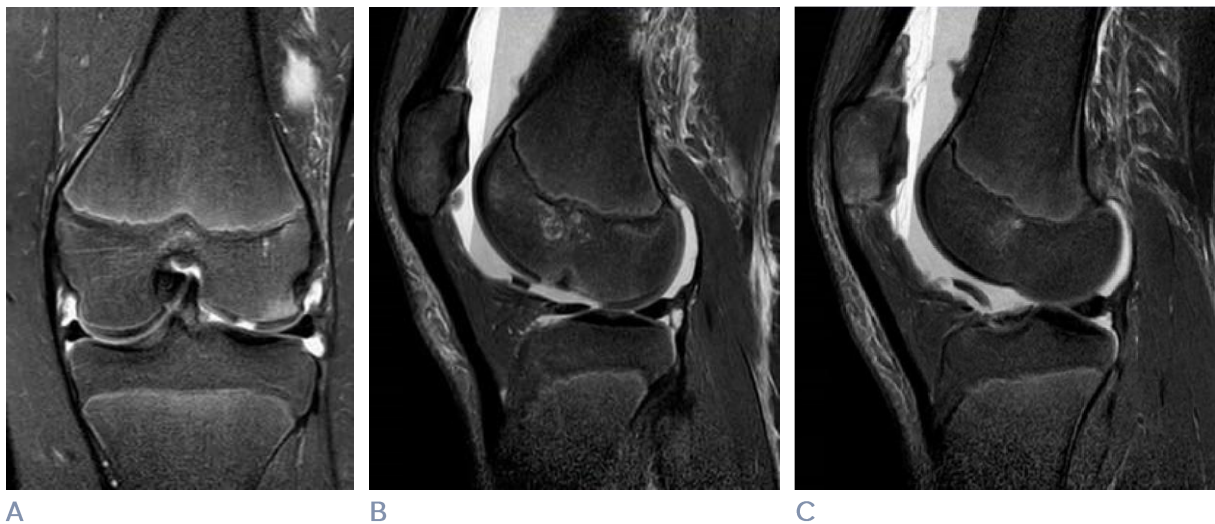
ePDW SPIR MRI sequences showing the osteochondral defect on the lateral femoral condyle (A, B) and the loose osteochondral body located in the notch (C).
